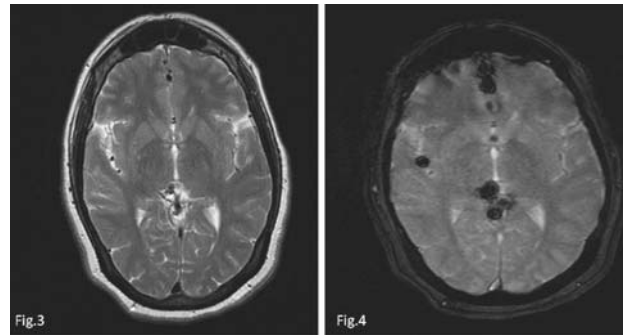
T2-weighted image of brain showing subtle small hypointense foci in the anterior and posterior aspects of interhemispheric fissure.
